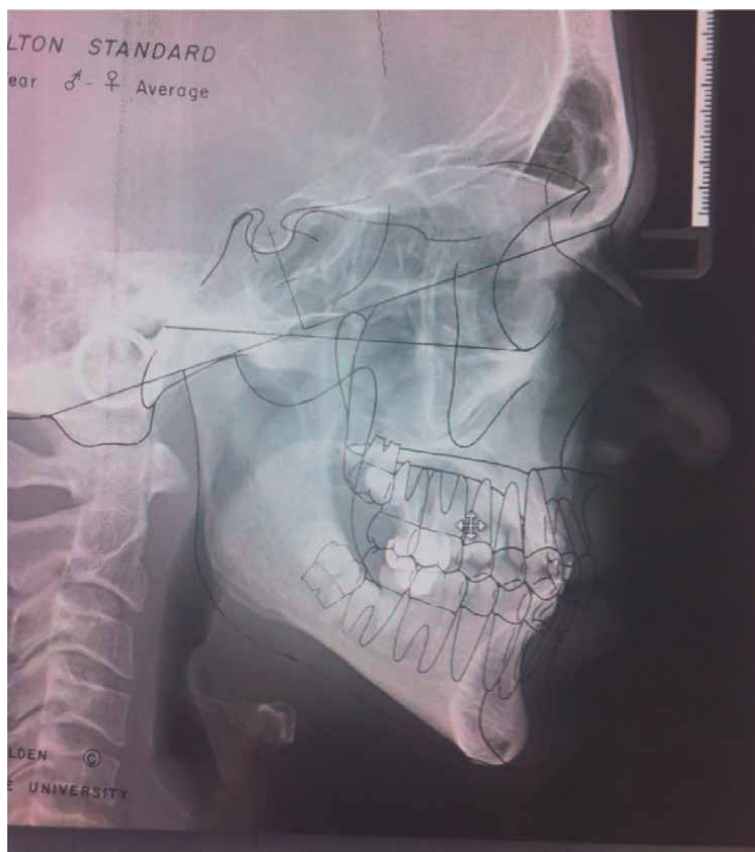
Cephalometric radiograph of a patient with PHT where we can measure a smaller jaw size and reduced skeletal development.
